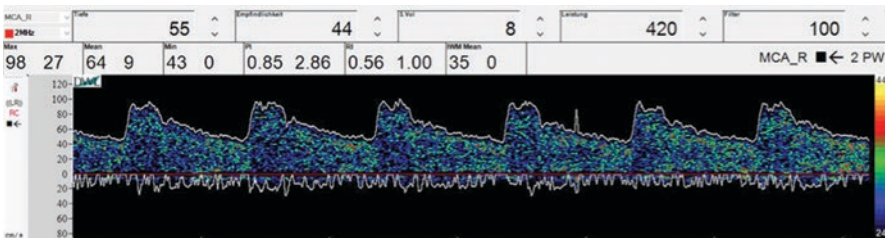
Example of transcranial Doppler (TCD) using pulsed Doppler system operating at 2 MHz emitting frequency showing the velocity parameters of middle cerebral artery
